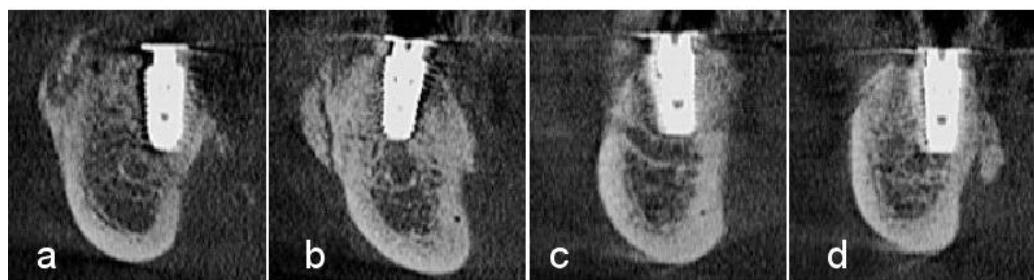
Postoperative CBCT scan images. Note successful 3-dimensional ridge augmentation
